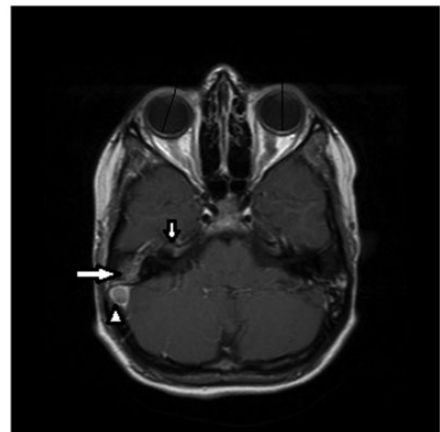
A coronal T2-weighted image shows medial deviation of the right globe secondary to cranial nerve VI palsy (lines).
